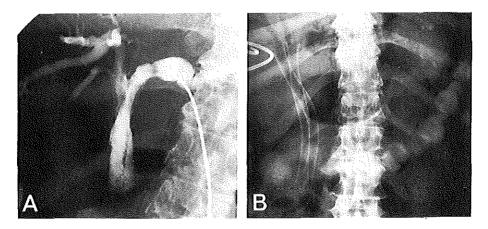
(a) Cholangiogram of a patient with gallbladder carcinoma and recurrent jaundice two months after stent placement. Cholangiogram was obtained after drainage of the left lobe hepatic bile ducts and shows blockage at the distal end of the stents. After drainage of the right lobe hepatic bile ducts, both stents and the stenosis distal to the stents were passed. Another two stents were then placed. (b) Abdominal radiograph obtained after extension of both stents into the duodenum. The right-sided catheter was removed after it became clear that the stents were functioning well.
